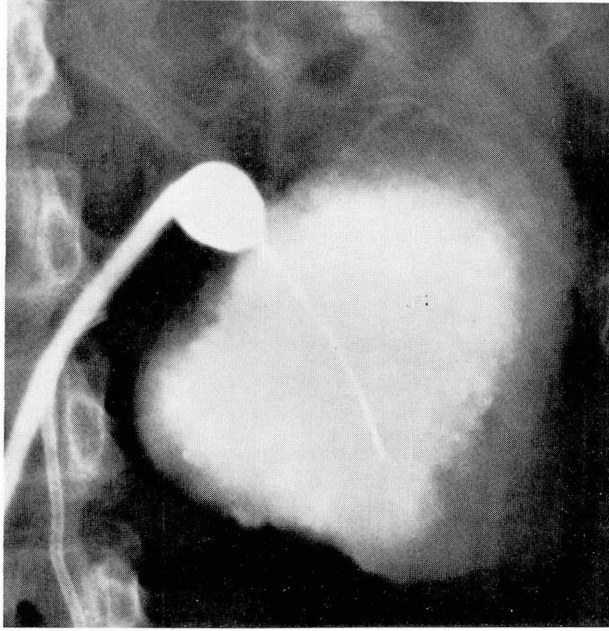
Injection of contrast medium into cystic mass involving lower pole of left kidney in a 19-year-old girl. Roentgenographic appearance of an irregular, shaggy, and relatively thick wall in this lesion strongly suggests the possibility of neoplasm. Radical nephrectomy was subsequently performed with removal of a necrotic renal cell carcinoma. There has been no evidence of seeding of tumor along the needle tract, and the patient is alive and well more than 4 years after operation.
